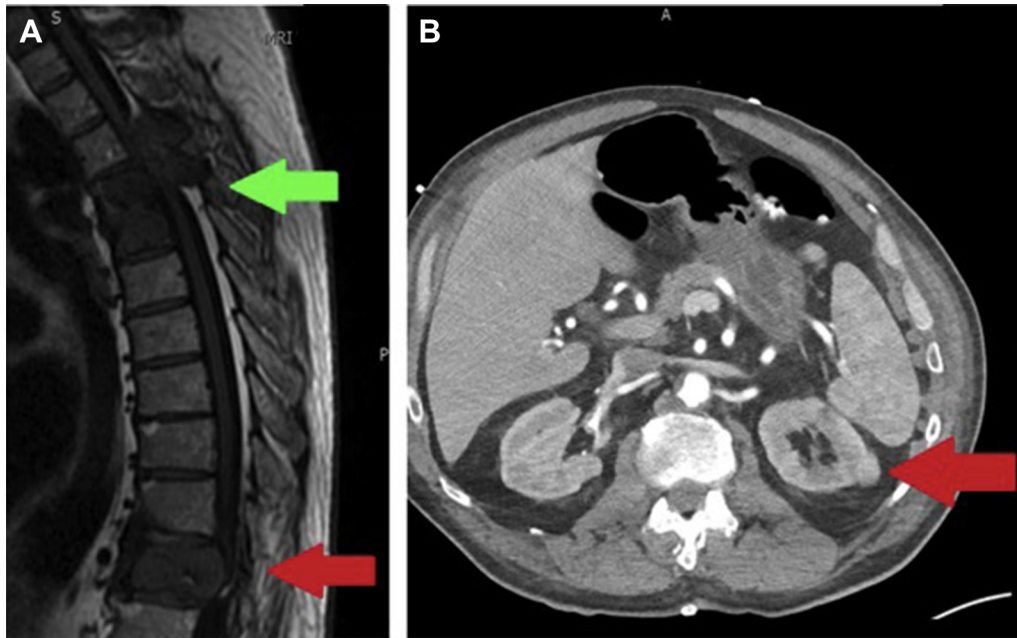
(A) T1-weighted MRI of the thoracic and lumbar spine demonstrating metastatic tumor compression of the thecal sac and spinal cord at T3-T5 (green arrow) and T11 (red arrow). (B) CT with contrast of the abdomen demonstrating 1.6 cm left renal mass (red arrow).
